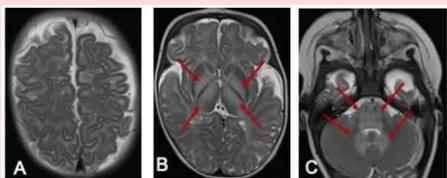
MRI brain at 7 months
